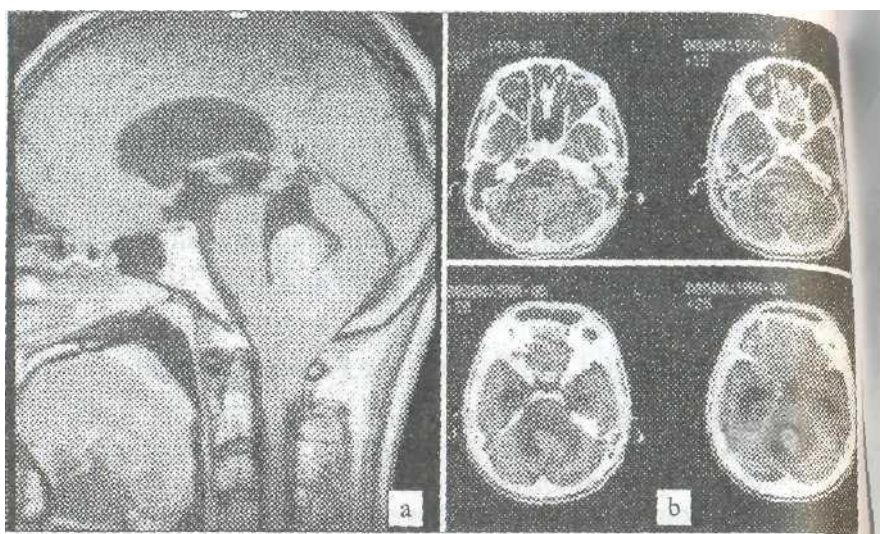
Ependymoma, a) MR I. b) CT
